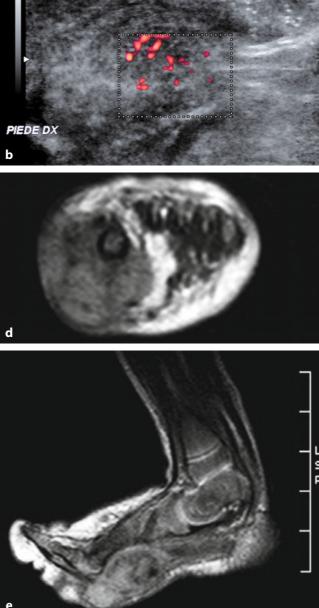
Foot congenital fibrosarcoma. Ultrasound: hypoechogenic lesion with calcification (a), ipervascularisation at power Doppler (b). MR imaging T1 (c) and T2 (d–e). (Courtesy Dr. Marcello Napolitano)
